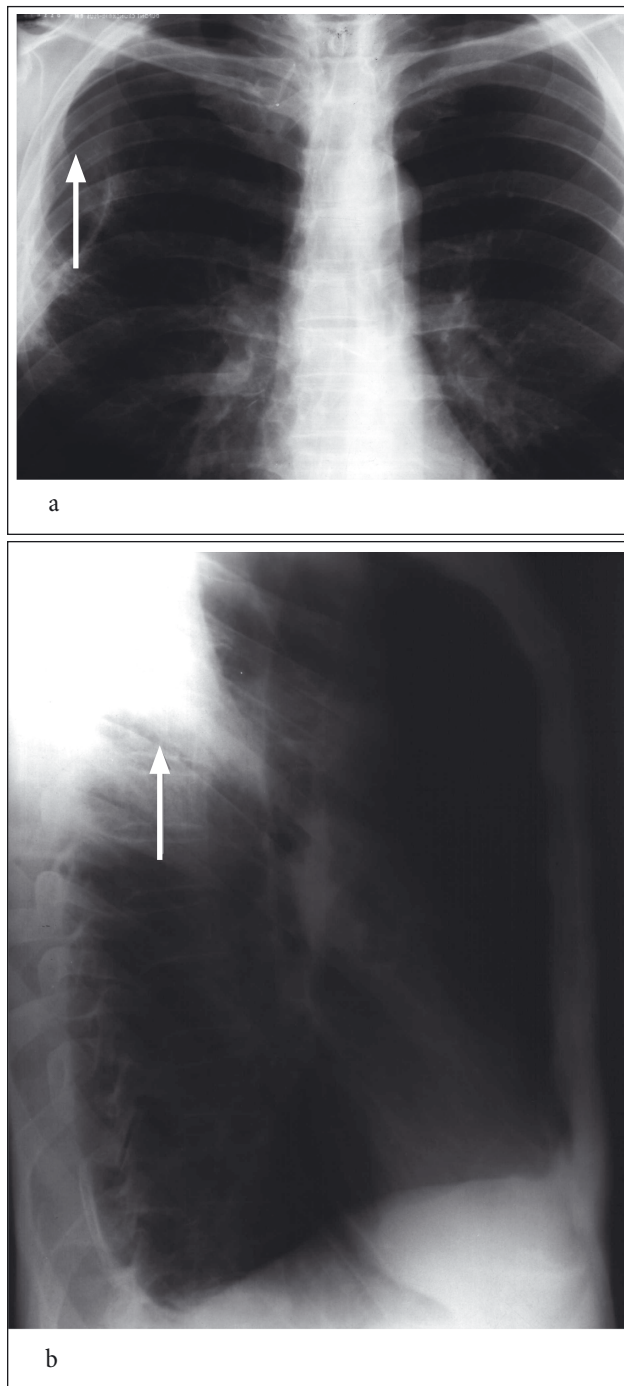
AP (a) and lateral (b) chest X-ray radiograms show 6.0 x 3.5 cm thin wall bulla with surrounding lung infiltration and hilar reaction in the superior lobe of the right lung
